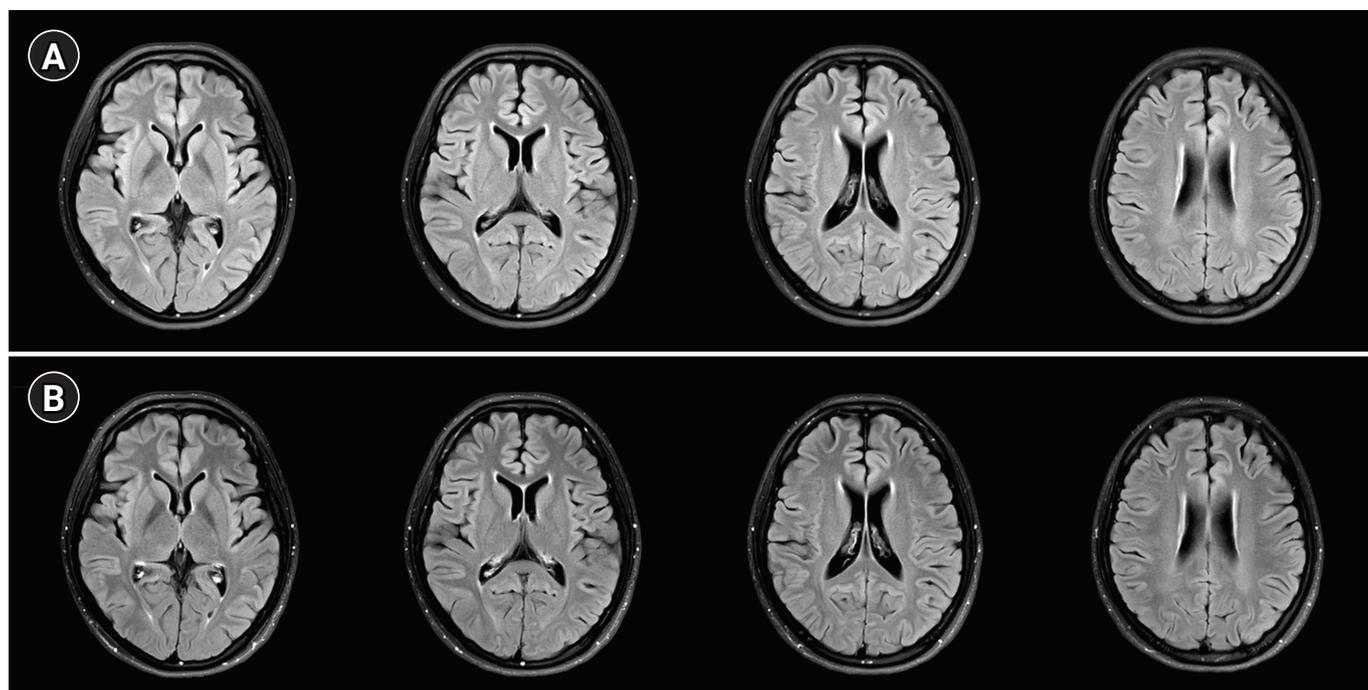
Brain magnetic resonance imaging performed 3 months after rituximab treatment. Fluid-attenuated inversion recovery (FLAIR) image (A) and FLAIR-enhanced image (B) showed no abnormalities.
